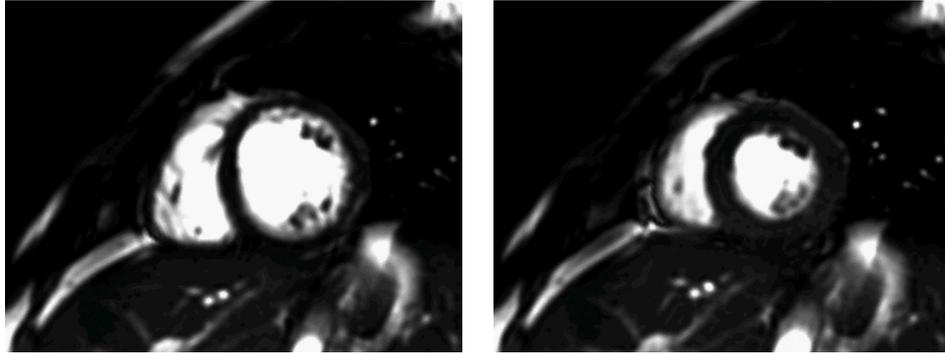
Diastolic (left) and systolic (right) short-axis slices of a cine MRI scan obtained from a dilated cardiomyopathy patient.
